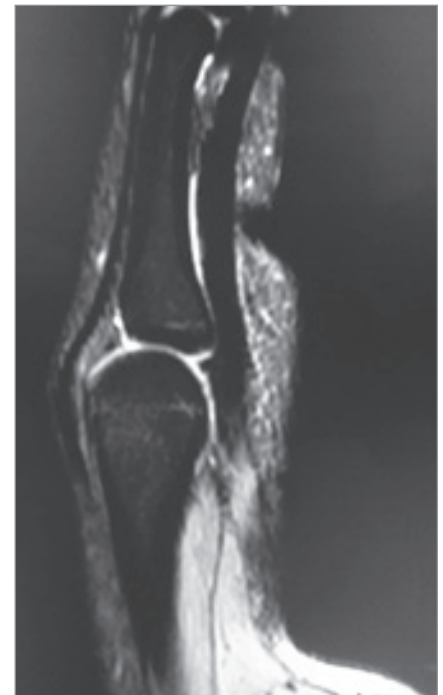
Postoperative MRI: reposition of the basis of the proximal phalanx.
